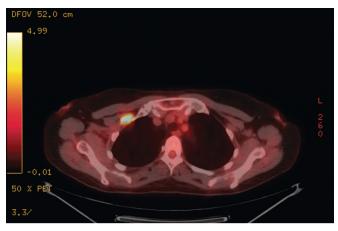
Figure G-2 Axial PET/CT slice of a patient with a right breast cancer that involved the level III axilla and infraclavicular fossa. The involved lymph node is below and medial to the pectoralis minor muscle. *CT*, computed tomography; *PET*, positron emission tomography.
